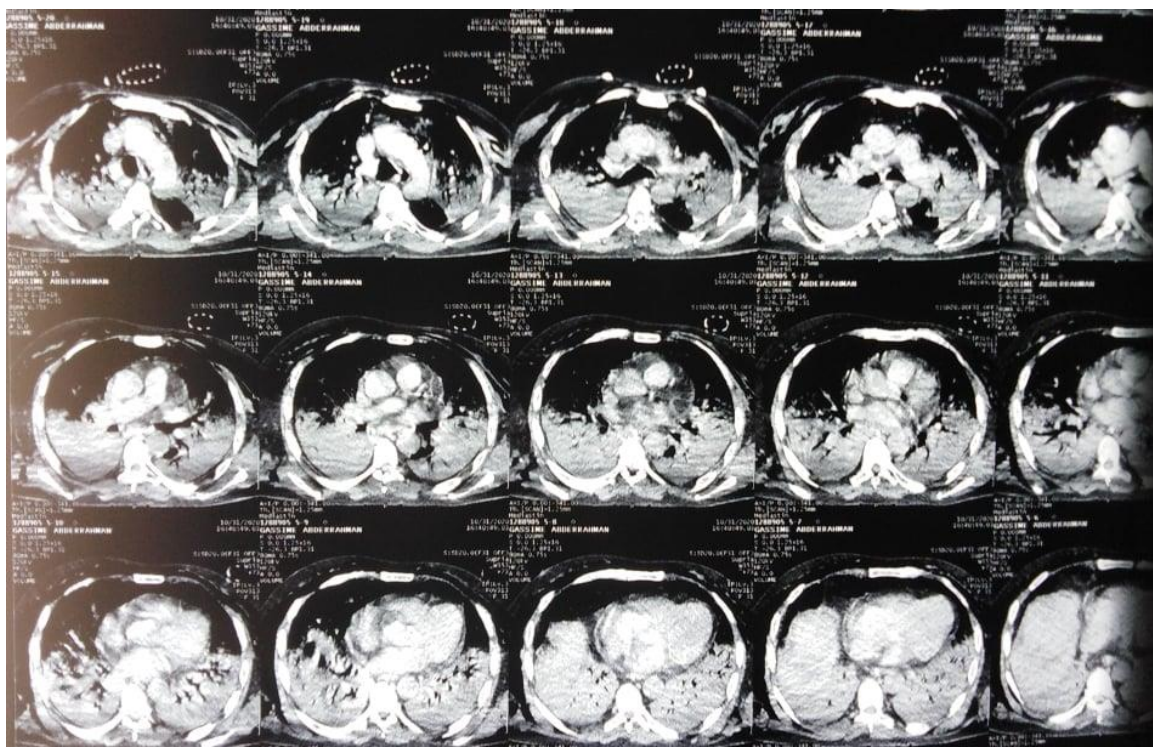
Chest computed tomography without contrast injection (parenchymal windows). Axial sections showing the presence of pneumomediastinum associated with significant thoracic subcutaneous emphysema. It associated with ground glass opacities related to a critical COVID-19 viral attack
